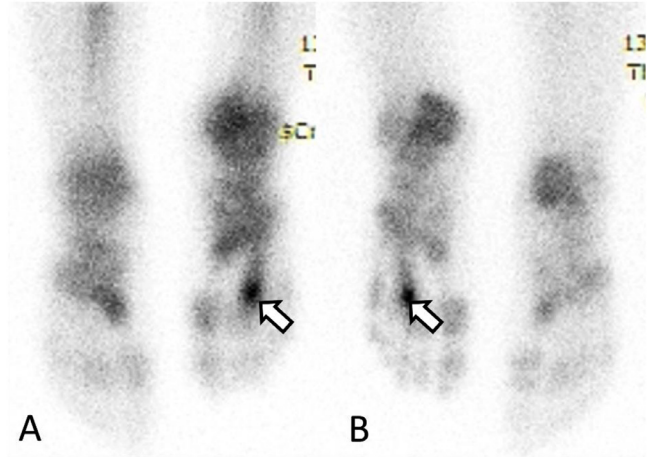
A/P view of bilateral bone scintigraphy of the feet clearly shows a focus of increased captation in the tumor site.
